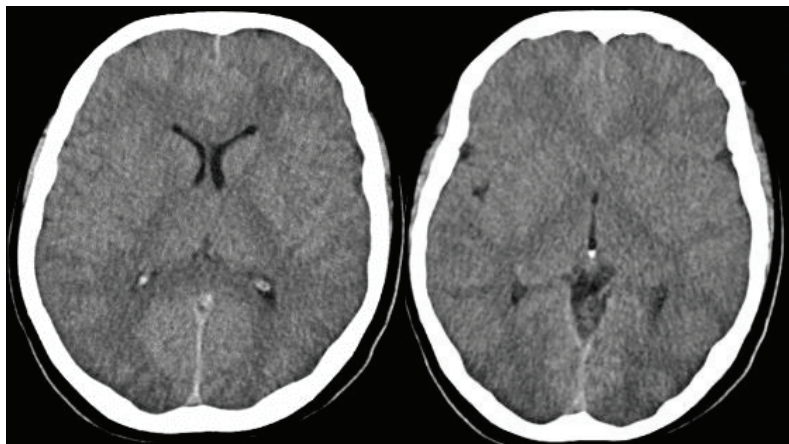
Initial brain CT scan, with normal findings
